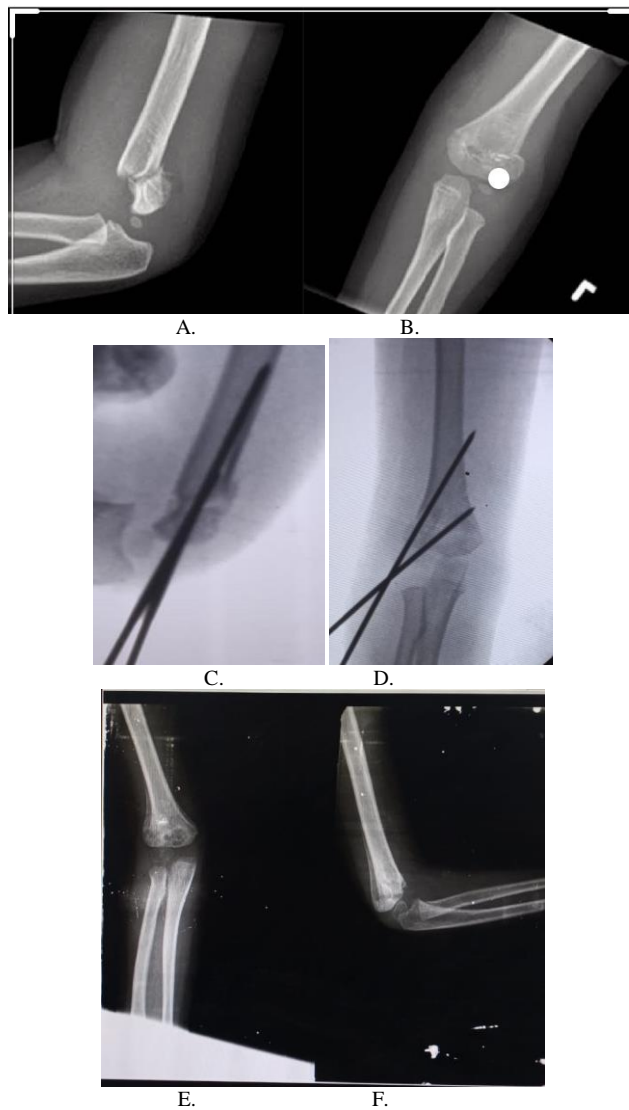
Type IIB supracondylar fracture of humerus in 4-year-old. (A and B) Preoperative radiographs. (C and D) After stabilization with two Lateral K-wires and Follow up x-rays at 6 weeks(E and F)
